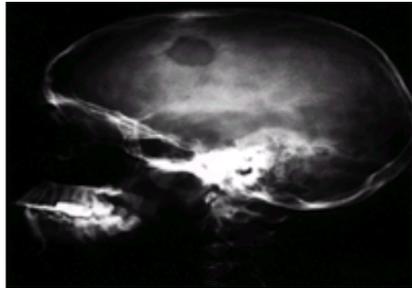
This is a lateral plain radiograph of the skull of a patient with a solitary Langerhans cell histiocytosis (eosinophilic granuloma). The skull is the single most common site of involvement for eosinophilic granuloma. Plain radiographs of the skull are recommended when eosinophilic granuloma is suspected. These lesions rarely require treatment.
